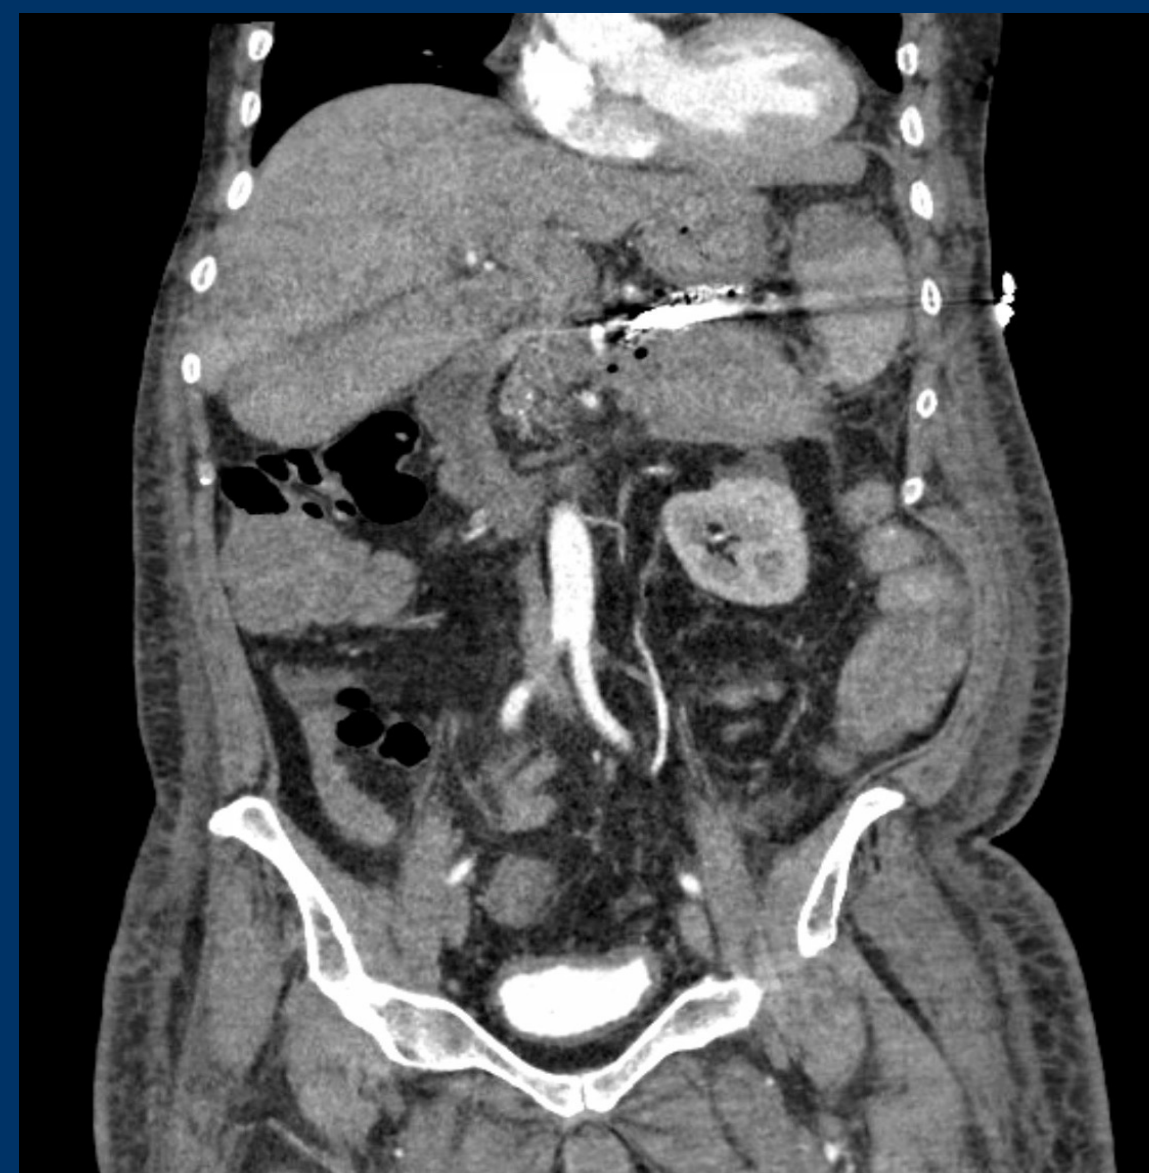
CTA Abdomen demonstrating marked distension of the gallbladder with hyperdense material within the gallbladder lumen concerning for acute hemorrhagic cholecystitis.
